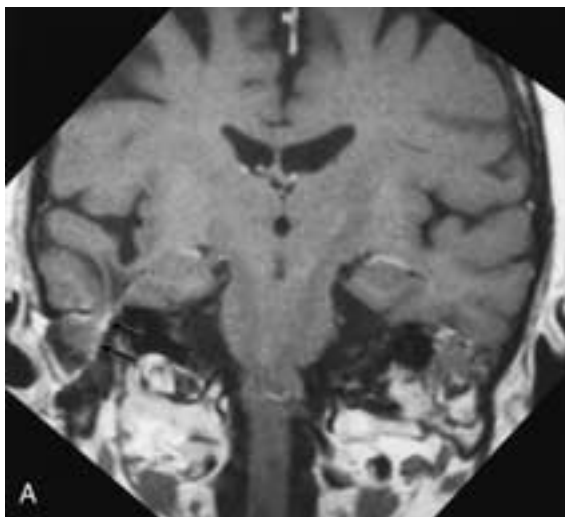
Posttraumatic meningoencephalocele. A, Coronal T1-weighted postcontrast image. B, Coronal T2-weighted fast spin-echo image. There is tegmen disruption on the right side. Note the herniation not only of the meninges into the attic but also of a portion of the inferior temporal gyrus (*arrows*). There is debris within the left middle ear cleft as well.
